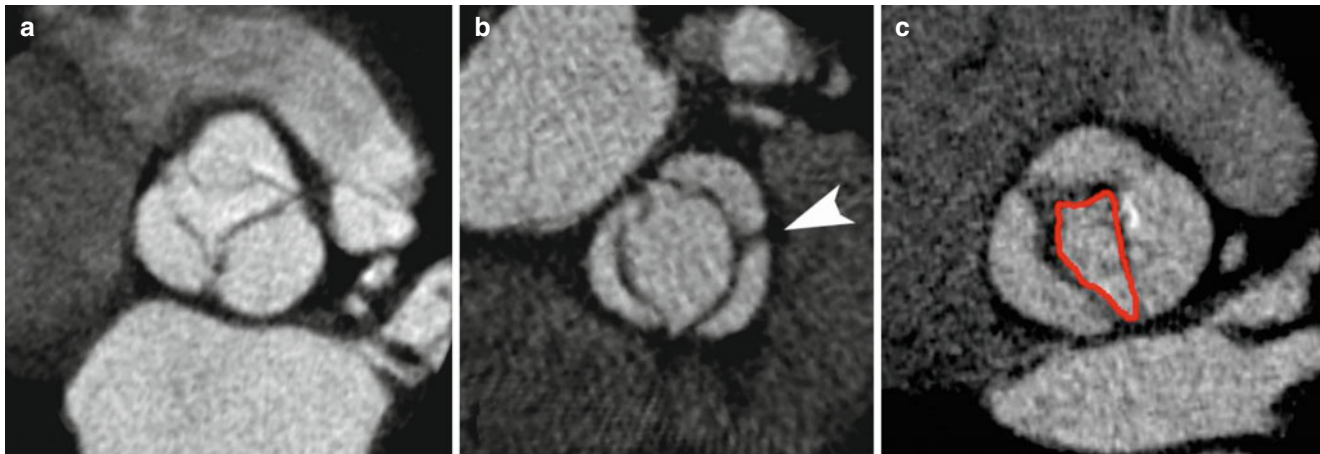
Double oblique systolic reconstructions of contrast-enhanced CT scans showing a tri-leaflet (panel a) and a bicuspid aortic valve (the *arrowhead* indicates the fusion of the right and left coronary
